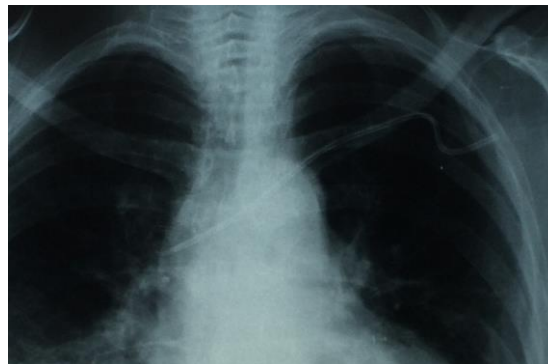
plain x-ray showing misplaced CVC abutting on wall of the SVC;
